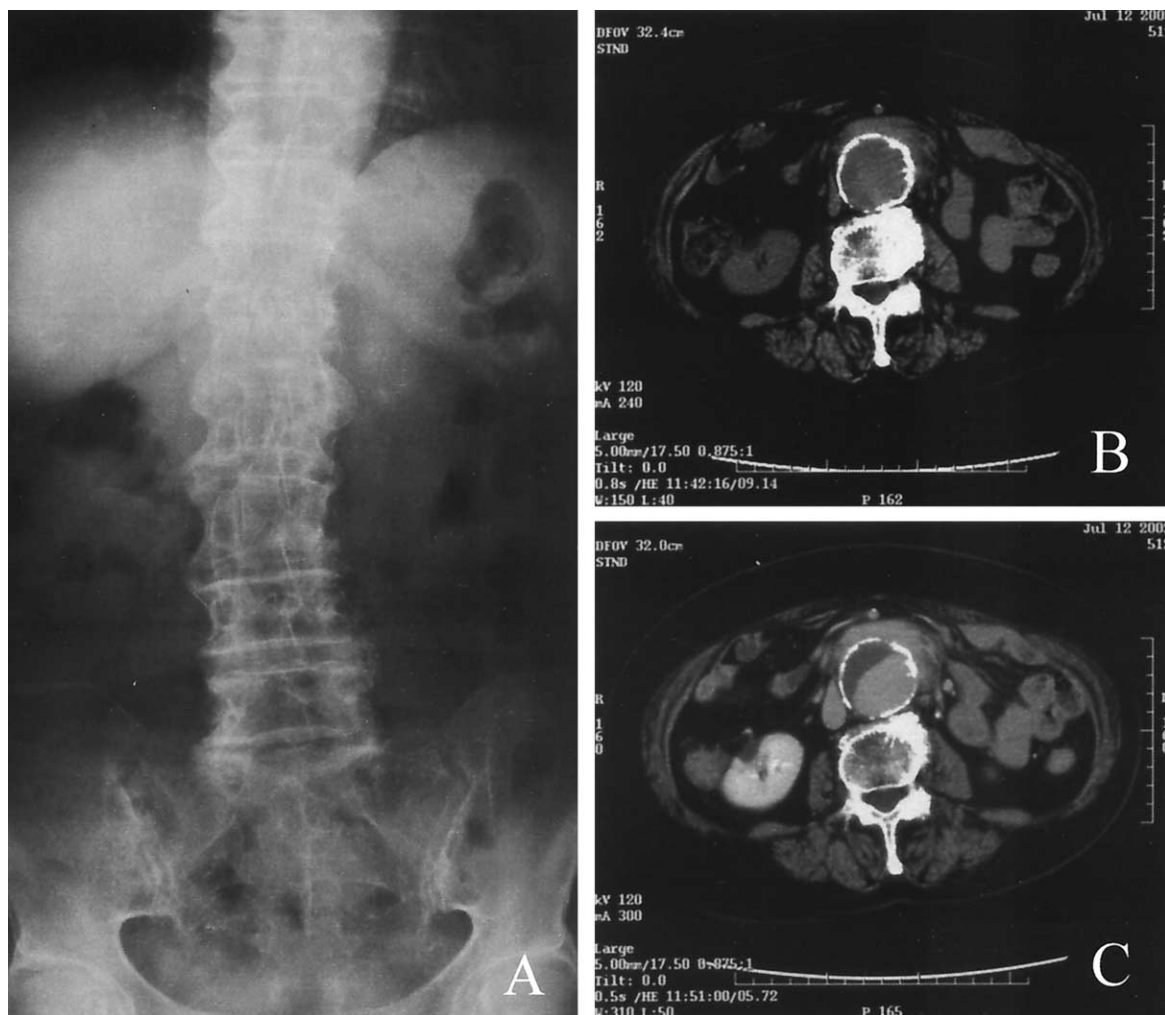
A, Abdominal x-ray film demonstrates characteristic deformation of the lumbar vertebrae, so-called bamboo spine. B, Non-contrast-enhanced CT scan reveals an abdominal aortic aneurysm, 48-mm in maximum diameter. C, Contrast-enhanced CT scan shows contrast-enhanced, thickened aortic wall along an anterior aspect of the aneurysm.
